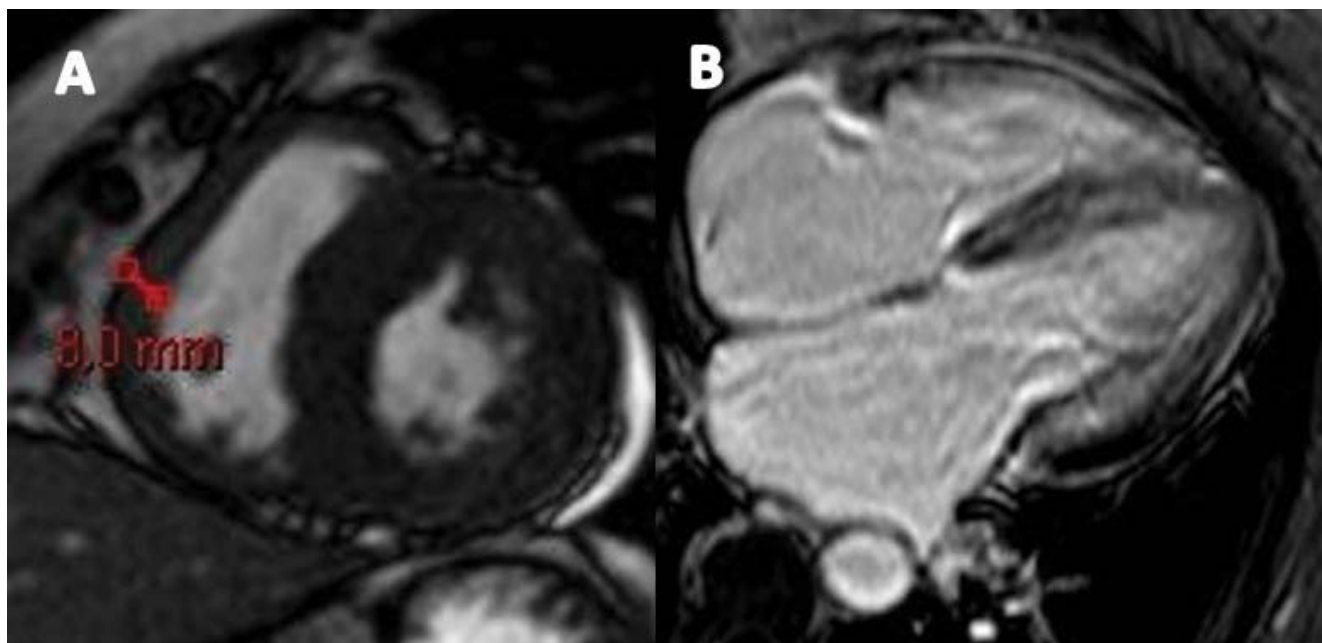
Cardiac magnetic resonance images showing A. an increase in right ventricle wall thickness (8 mm). B no LGE of the right ventricle. LGE: late-gadolinium enhancement.
